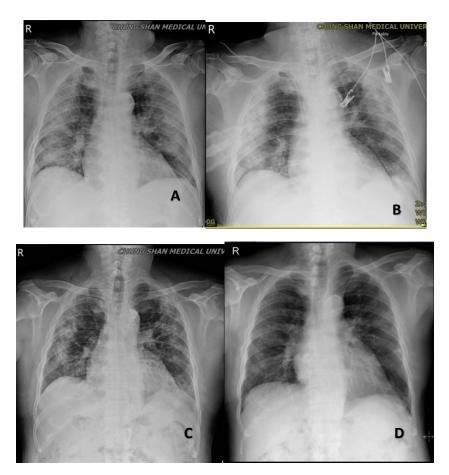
Chest radiography in a patient with COVID-19 on day 10 after symptom onset revealed reverse batwing sign (A); persistent bilateral lung consolidation on day 23 despite antibiotic and antiviral treatment (B); improvement on day 30 after steroid treatment (C); and resolution of opacities on day 55 (D).
